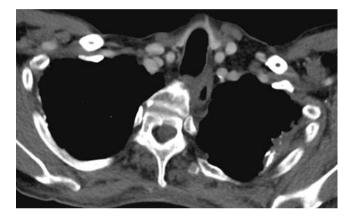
Pleural calcification in a patient with previous hemothorax with old rib fractures (not shown) on axial CT image
